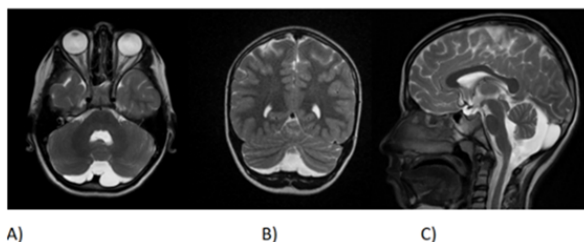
The patient's medical history includes an operation for an inguinal hernia. Additionally, cranial MRI imaging of the patient revealed hypoplasia in the lower cerebellar vermis.
